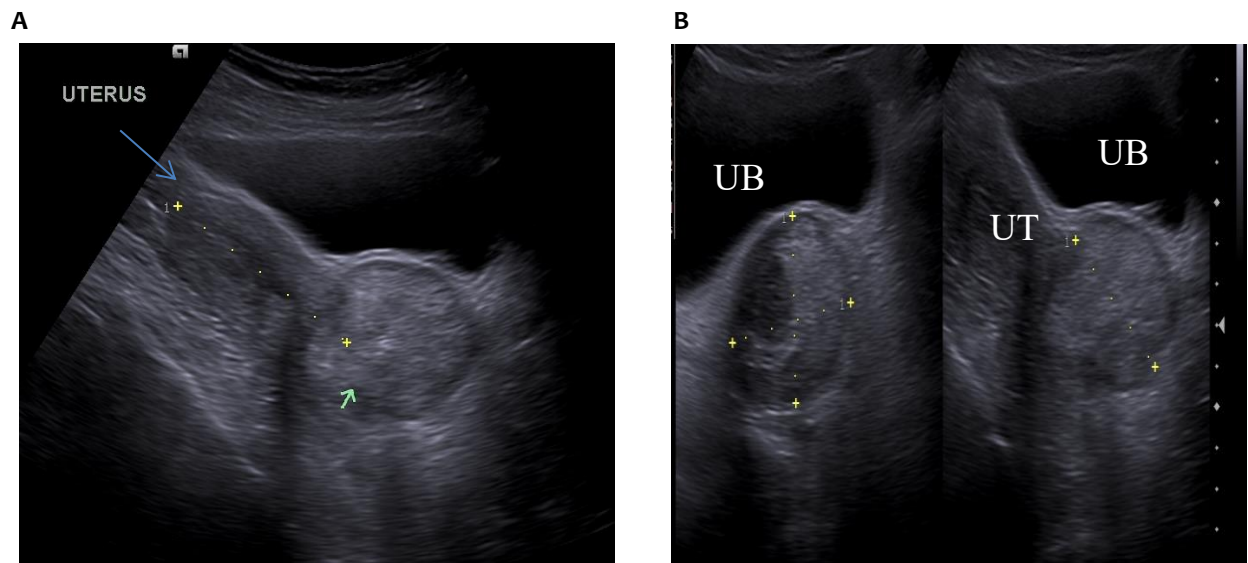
A: An ultrasound image showing a cervical mass (arrow). B: Transverse and sagittal images denoting the dimensions of the cervical mass.
